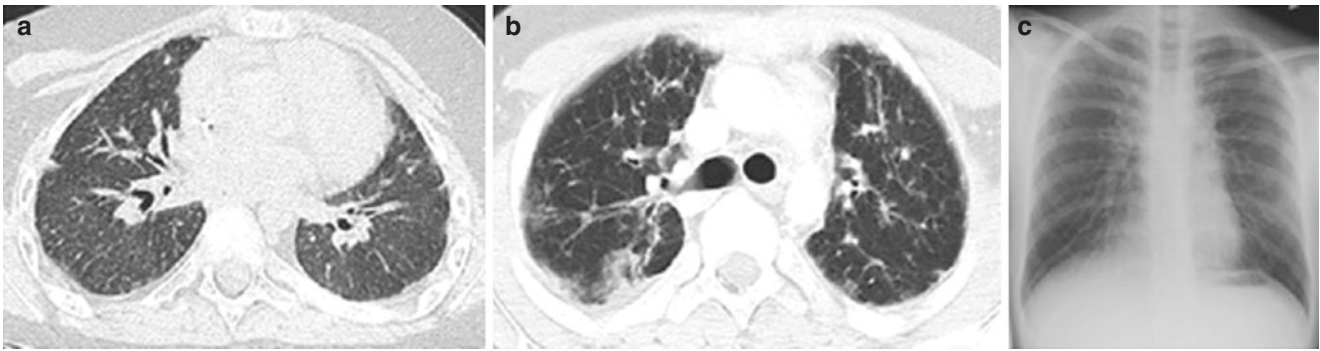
(a) Fibrosis: the patient has had prior chemotherapy and bone marrow transplant (BMT). Axial lung window CT image reveals diffuse intralobular septal thickening consistent with pulmonary fibrosis. (b) Axial lung window CT image in a different patient also after remote chemotherapy and BMT. There is coarse interstitial thickening
